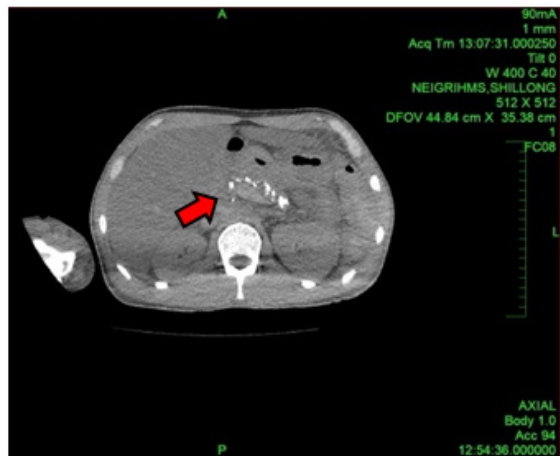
CT abdomen: calcified pancreas
